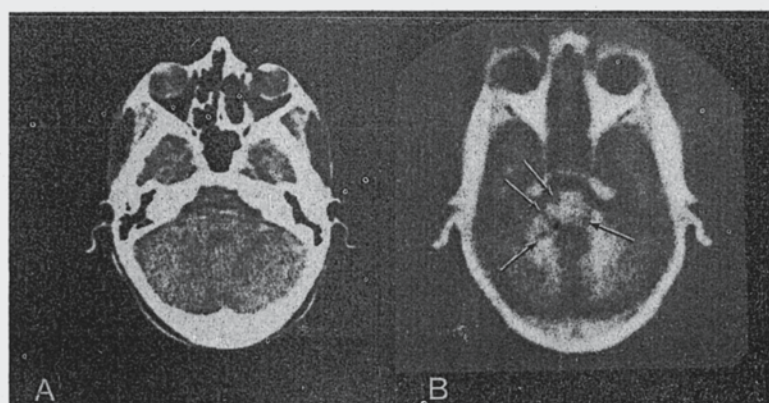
Comparable CT (A) and NMR (B) scans in patient 10 at pontine level.
